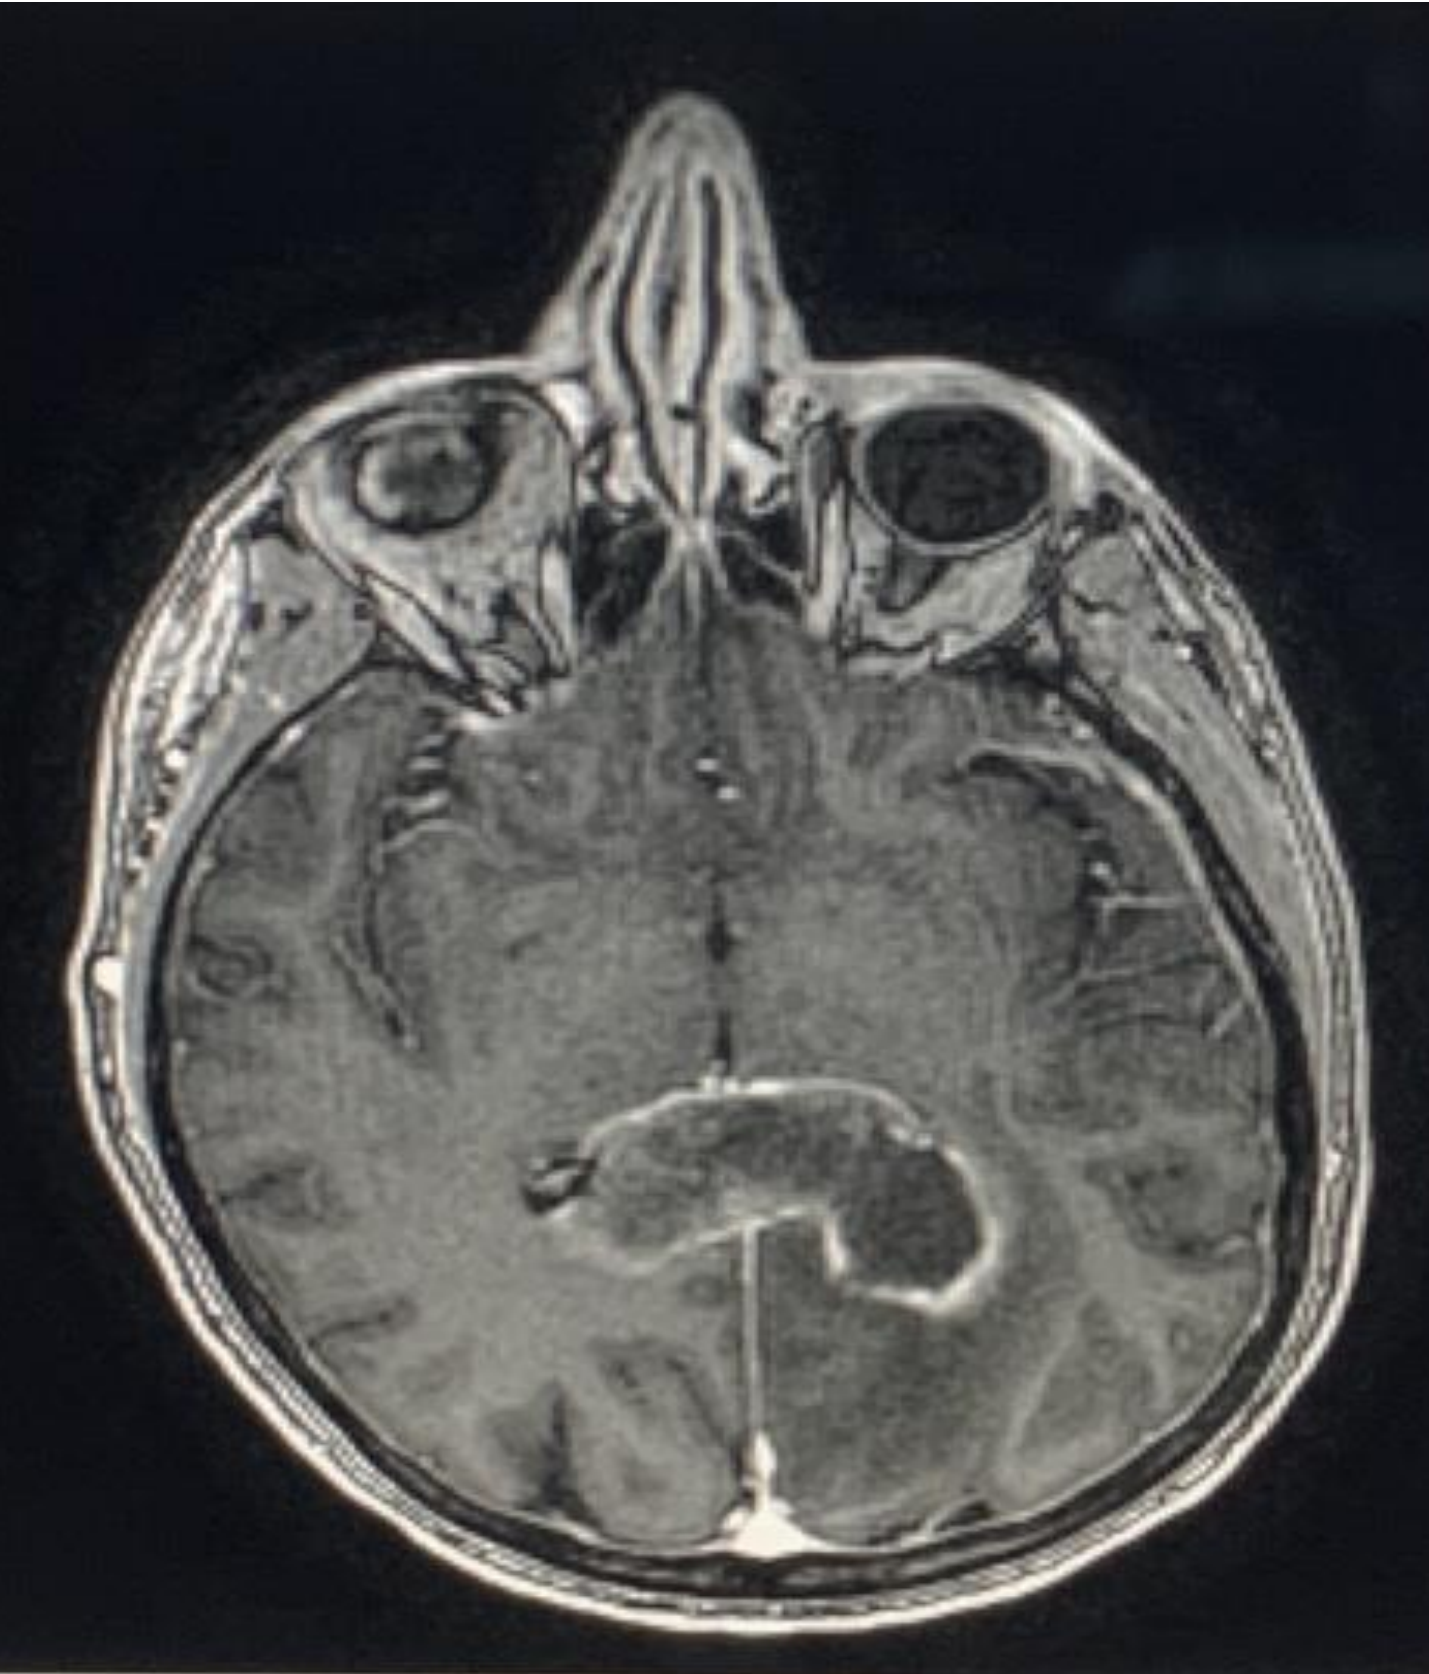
MRI scan, showing a heterogeneous mass extending across the splenium of corpus callosum, measuring 5.8 x 3.3 x 2.3 cm.
